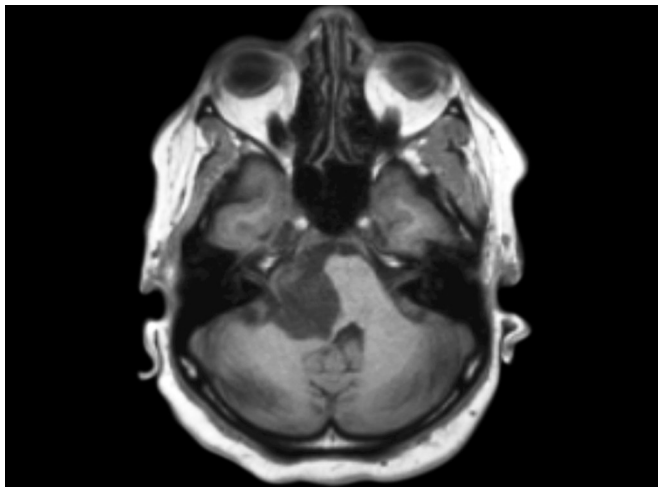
Cerebellopontine angle (CPA) epidermoid. Axial T1-weighted magnetic resonance imaging (MRI) of a CPA epidermoid demonstrating low signal intensity. Note the compression of brainstem and fourth ventricle.
